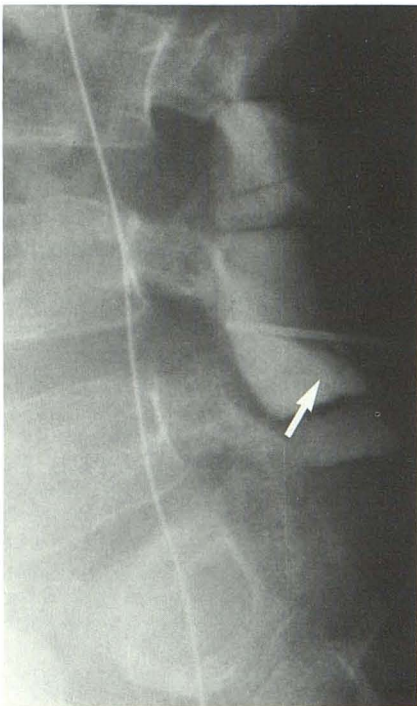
Lateral radiograph shows puncture of distended hydromyelic cavity within placode. Silastic stent (arrow) is faintly visible.
